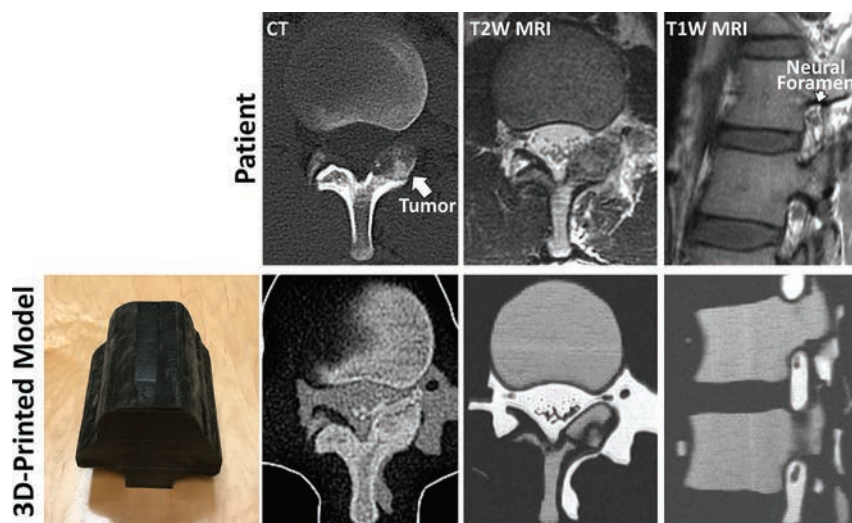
printed model of the lumbar spine (*bottom left panel*) of a patient with L1 left lamina osteoblastoma, designed to replicate the patient's anatomy as seen in the patient's diagnostic CT and MR imaging (*top row*). The outer *black* shell of the model is printed in a soft material to mimic soft tissue properties. CT of the 3D-printed model demonstrates cortical and cancellous bone with differential CT Hounsfield units, whereas MR imaging of the model demonstrates cancellous bone with intermediate and cortical bone with dark signal. Neural foramen and nerve root, key structures monitored during MR imaging-guided cryoablation as this patient underwent, are clearly visualized in the MR imaging of the printed model.
